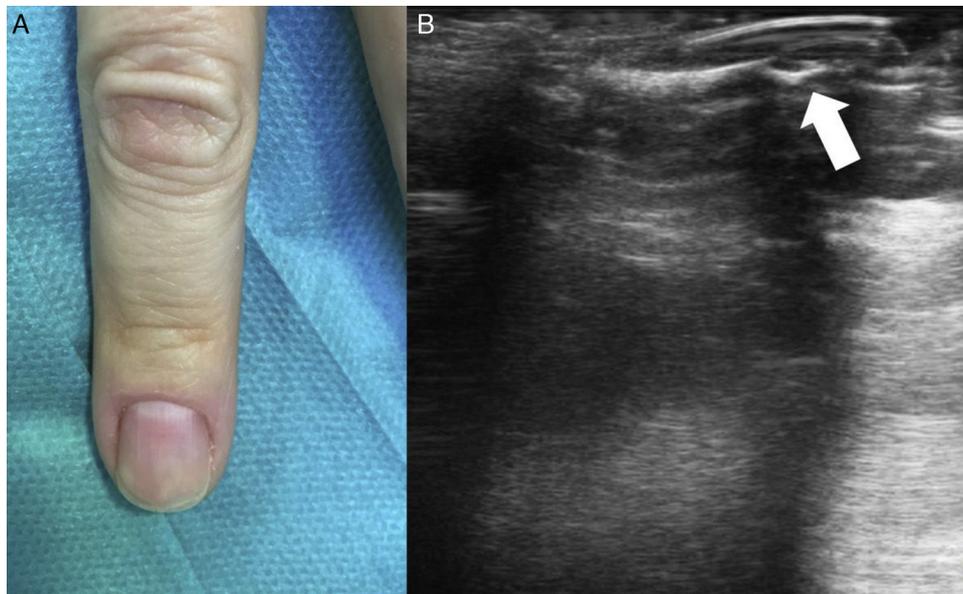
A, Normal clinical examination. B, B-mode ultrasound shows a well-defined, solid hypoechoic lesion with an oval form and regular borders measuring 3.1 mm in diameter.
